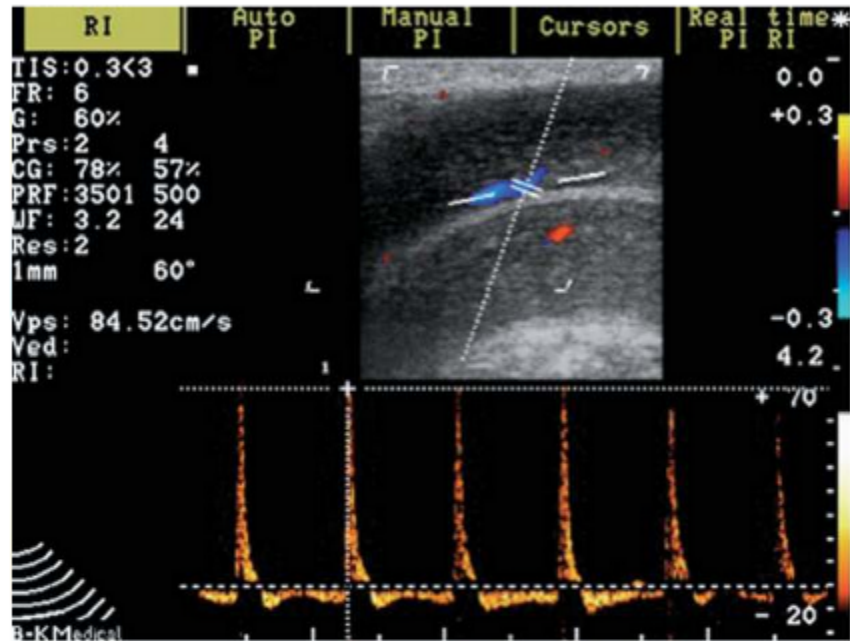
Real-time Doppler ultrasound scan with B-mode image of right cavernosal artery showing normal peak systolic velocity of 84.5 cm/second at peak erection response, suggesting a nonvascular etiology
